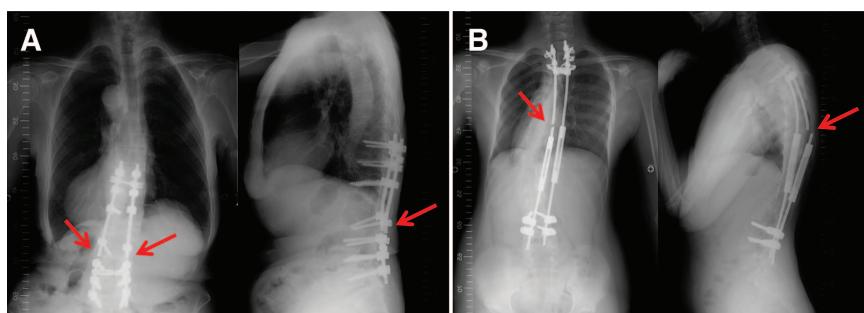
Coronal and sagittal radiographs of the rods removed from (A) the 71-year-old female and (B) the 11-year-old male after the rods had fractured. The arrows indicate the points where the rod fractures occurred.
